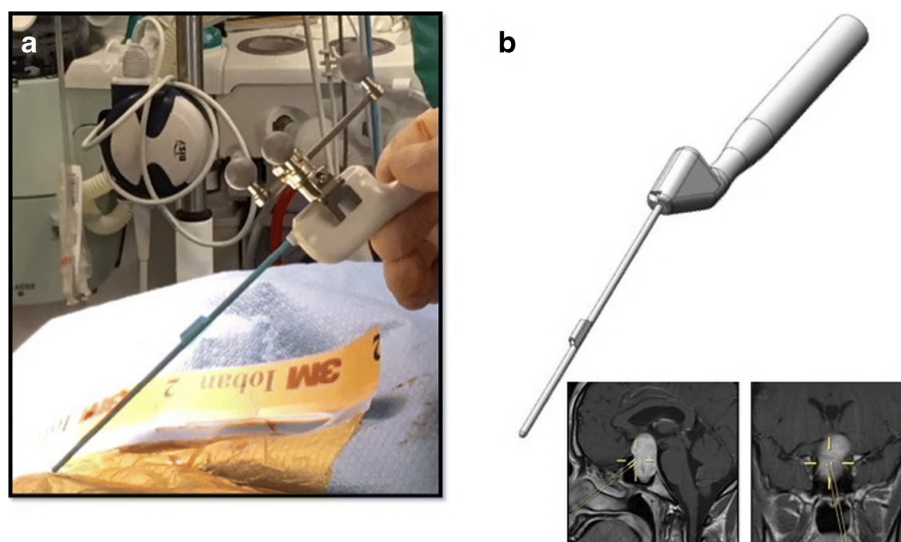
a) Intraoperative IOUS probe and its simultaneous use in neuronavigation for guidance (see MRI images bottom right). b) 3D model of the ultrasound probe. Reprinted from [37] with permission.
